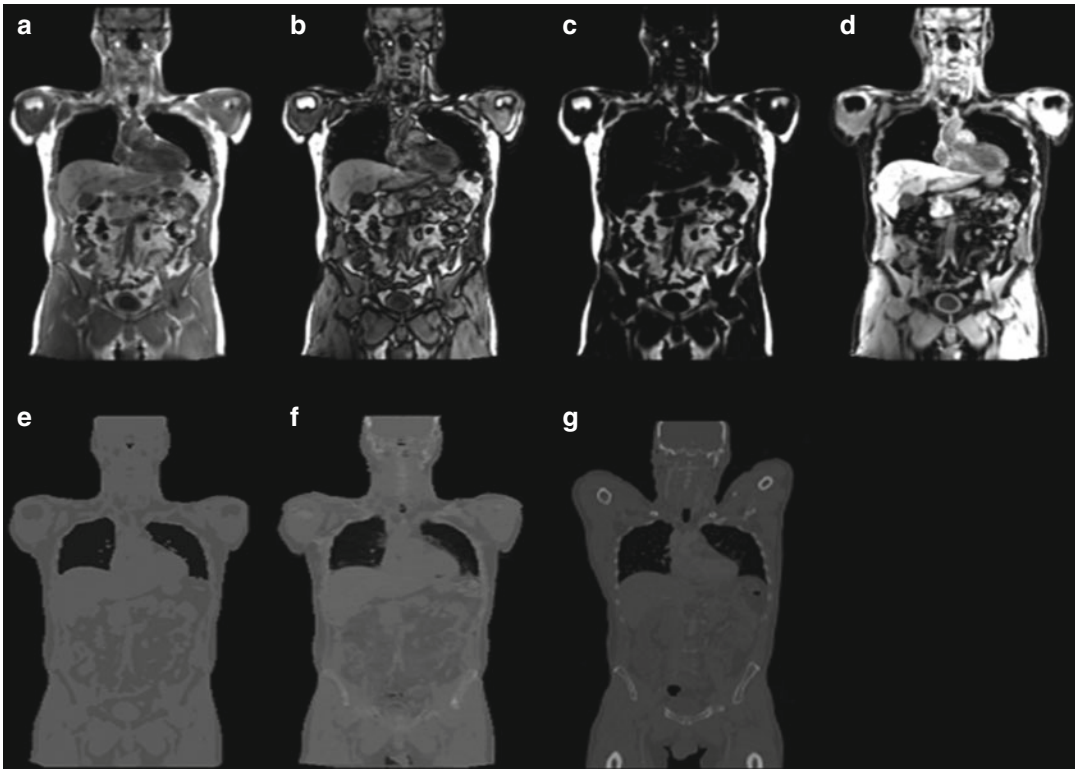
Upper row: a sample MR data set acquired with a T1-weighted 3D gradient echo sequence with 2-point Dixon fat and water separation. (a) In-phase, (b) opposed phase, (c) fat, and (d) water images. Lower row: attenuation maps created from the MR data using (e) the segmentation
